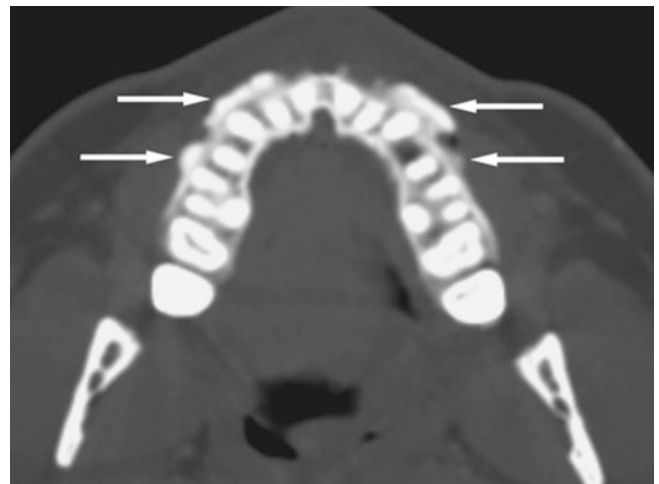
Multiple exostoses in the maxilla; painless hard swellings buccally in premolar region. Axial CT image shows multiple buccal exostoses bilaterally (*arrows*)
